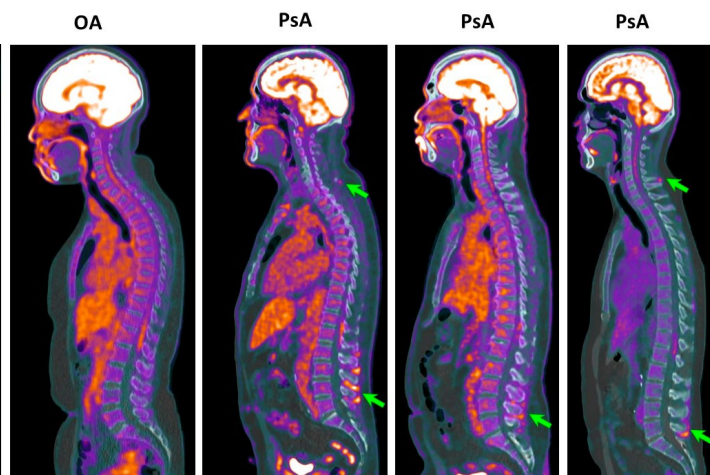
Enthesitis at multiple levels in the spine (green arrows) with or without sacroiliitis is an interesting finding in the psoriatic arthritis (PsA) patients by total body the PET-CT imaging. Whereas in osteoarthritis (OA) spinal inflammation could not be detected. Involvement of the inter-/supra-spinous ligament are marked by the green arrows.
